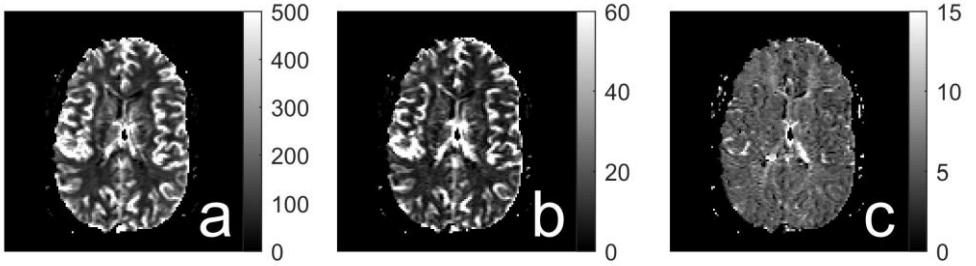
Images resulting from a standard DSC–MRI experiment showing (a) CBF (in ml/min/100 g), (b) CBV (in ml/100 g), and (c) MTT (in s) in a healthy volunteer.
